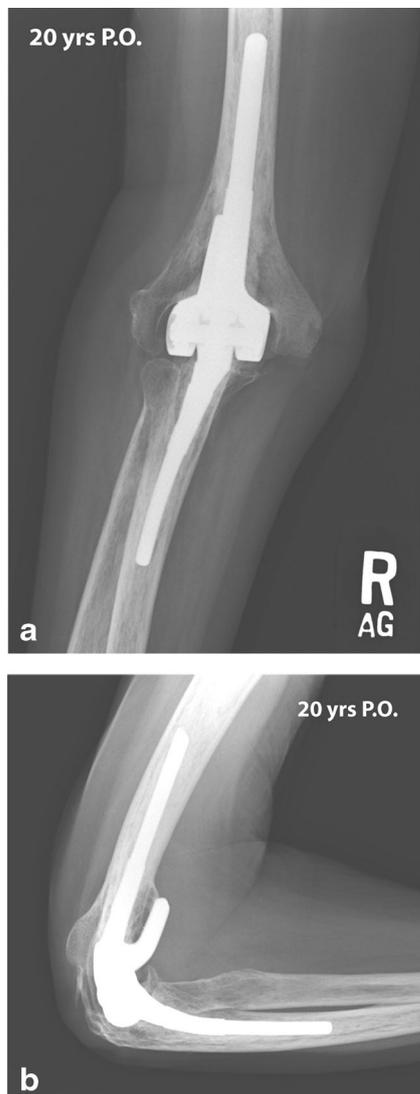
Radiographs obtained at 20 years after elbow arthroplasty for rheumatoid arthritis. a Anteroposterior view. b lateral view
